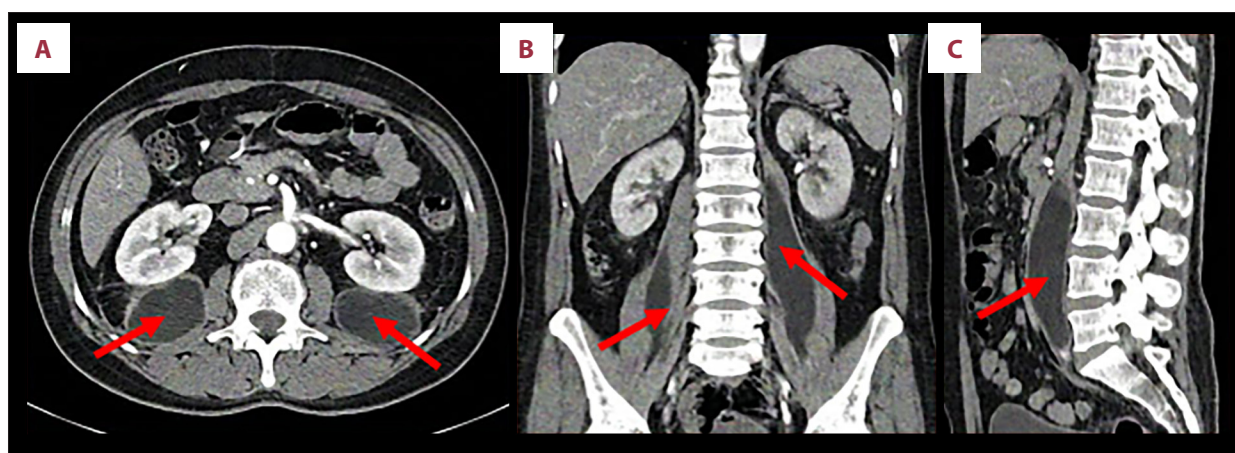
Follow-up contrast-enhanced computed tomography scan of the abdomen and pelvis. Follow-up imaging displayed in the (A) axial, (B) coronal, and (C) sagittal reconstruction planes demonstrate a significant reduction in the overall size, margins, and surrounding inflammatory stranding of the bilateral iliopsoas fluid collections (indicated within the solid red circles) following targeted intravenous antibiotic management.
